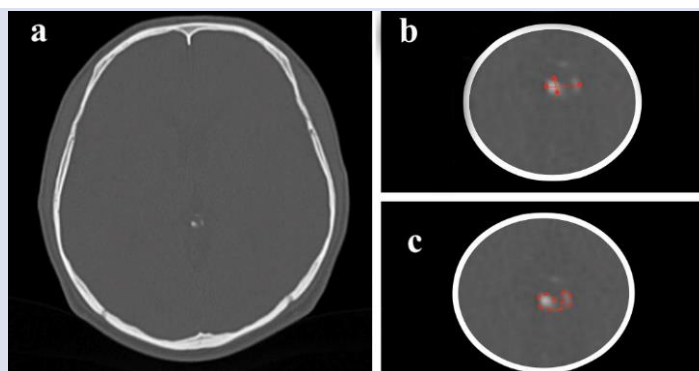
Axial cone-beam computed tomography (CBCT) section (a) and measurements of the anteroposterior and lateral dimensions (b) and area (c) of pineal gland calcification.
